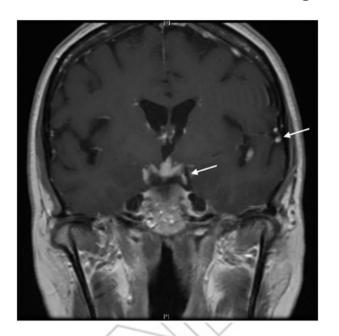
MRI pituitary, coronal T1 post-contrast image: leptomeningeal enhancement with nodularity involving both infra- and supratentorial regions, especially prominent around the suprasellar cistern and the optic chiasm (arrows). Courtesy of Dr Fang Zhu, Chicago.
